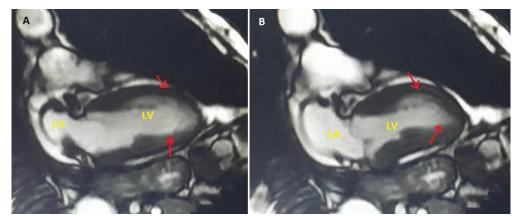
Cardiac MRI 2 chamber view shows the left ventricle in diastolic phase (A) and systolic phase (B) revealing severe dysfunction of the apex (red arrows). LV: left ventricle, LA: left atrium
